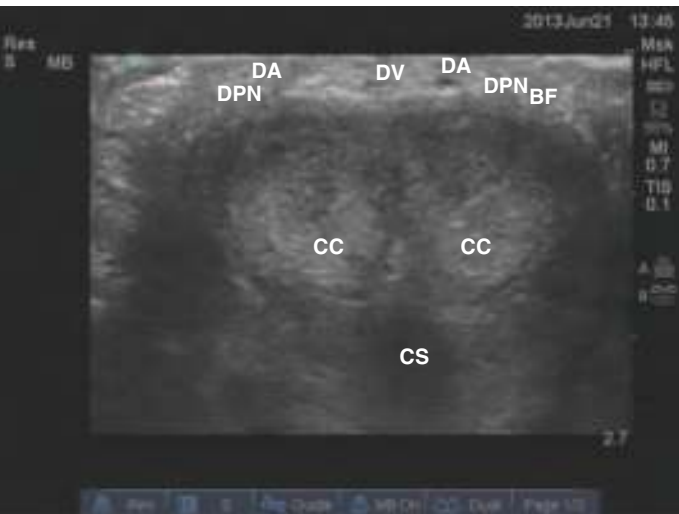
Ultrasound of the penis. DA, dorsal artery; DV, dorsal vein; DPN, dorsal penile nerve; BF, Buck's fascia; CC, corpus cavernosum; CS, corpus spongiosum. (Photo courtesy of M-I Suleman, from *Anesthesia News* 2015; 41(5):10-13.)
